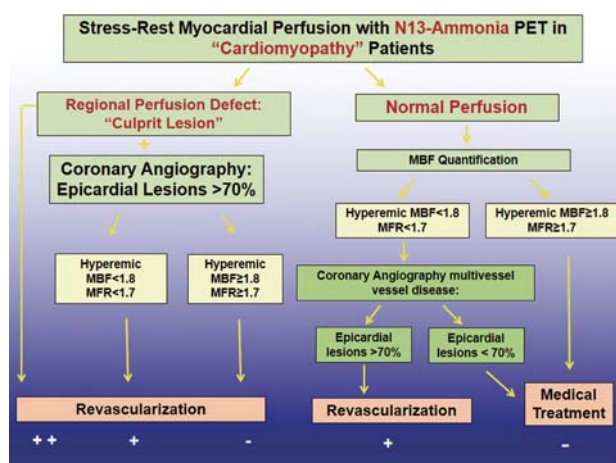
Algorithm for the Integration of ^{13}N -ammonia PET/CT Perfusion Images, hyperemic MBFs and MFR in Individuals with Cardiomyopathy
